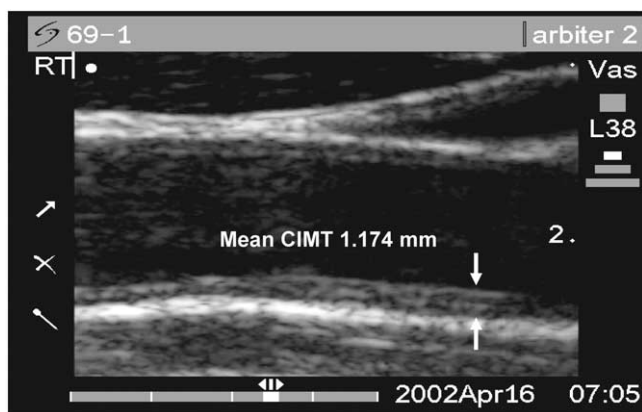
An example of an ultrasound image from the distal common carotid artery with quantification of intima-media thickness. CIMT = carotid intima-media thickness.
